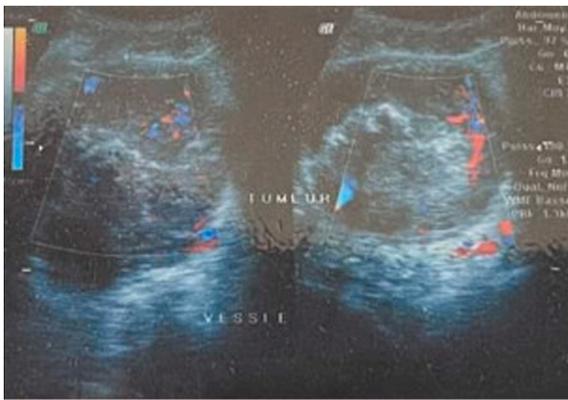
Bladder ultrasound showing a tumor in the trigone and the right wall.
